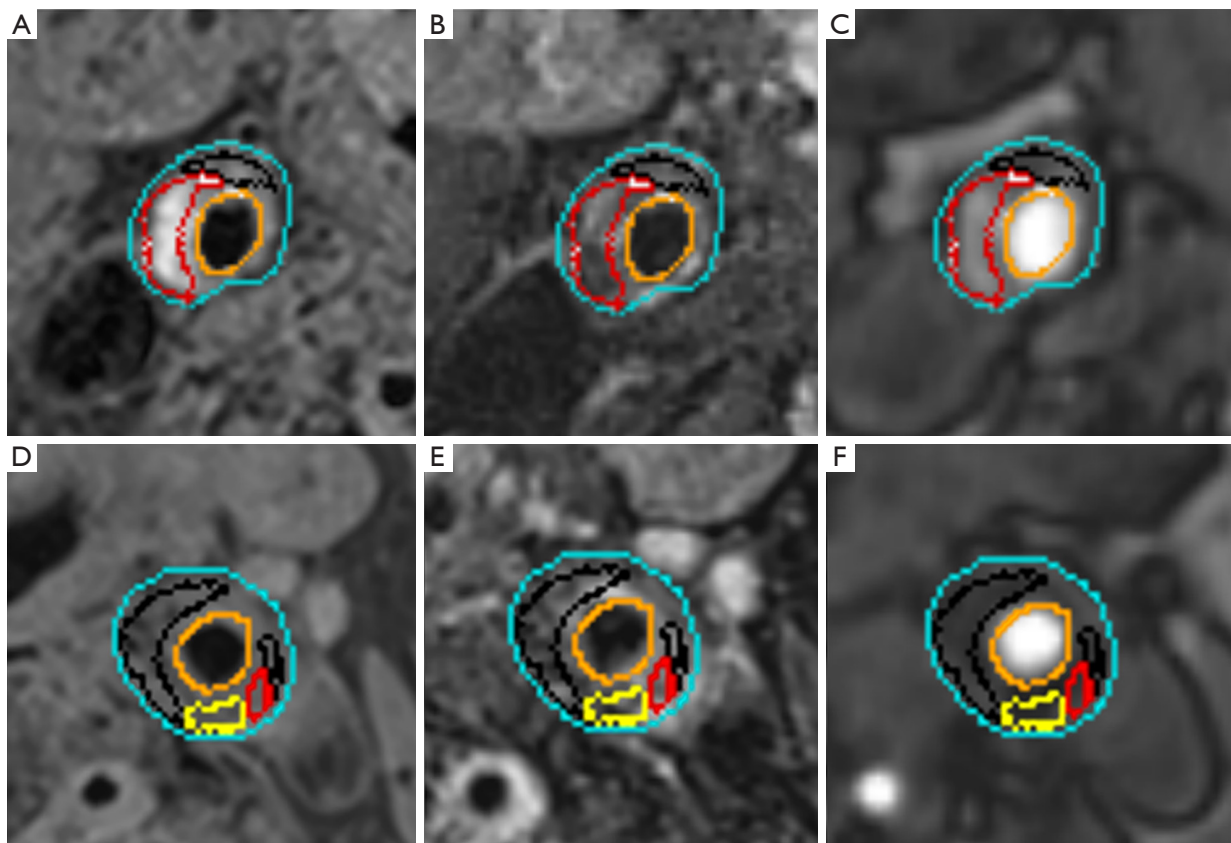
Carotid MRI semi-automatic segmentation of plaque composition. (A-F) The MR-PlaqueView vascular plaque imaging Diagnostic System was used to delineate the plaque component regions on T1WI, T2WI, and TOF sequences. Different colors indicate different plaque components. Orange represents the lumen; blue represents the wall; red represents IPH; black represents lipids; yellow represents calcification. (A-C) Atherosclerotic plaque with IPH (outlined in red) was detected in the right carotid artery of a patient. (D-F) Atherosclerotic plaques with large LRNCs (outlined in black) were detected in the left carotid artery of a patient. MRI, magnetic resonance imaging; T1WI, T1-weighted imaging; T2WI, T2-weighted imaging; TOF, time-of-flight; IPH, intraplaque hemorrhage; LRNC, lipid-rich necrotic core.
